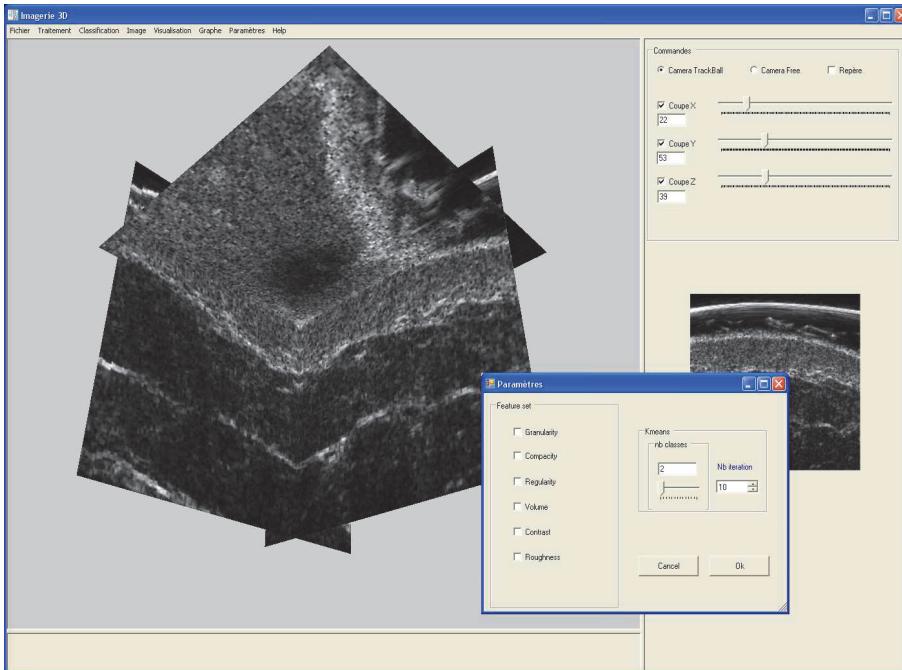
Interface of the proposed software for segmentation of 3D ultrasound images.
